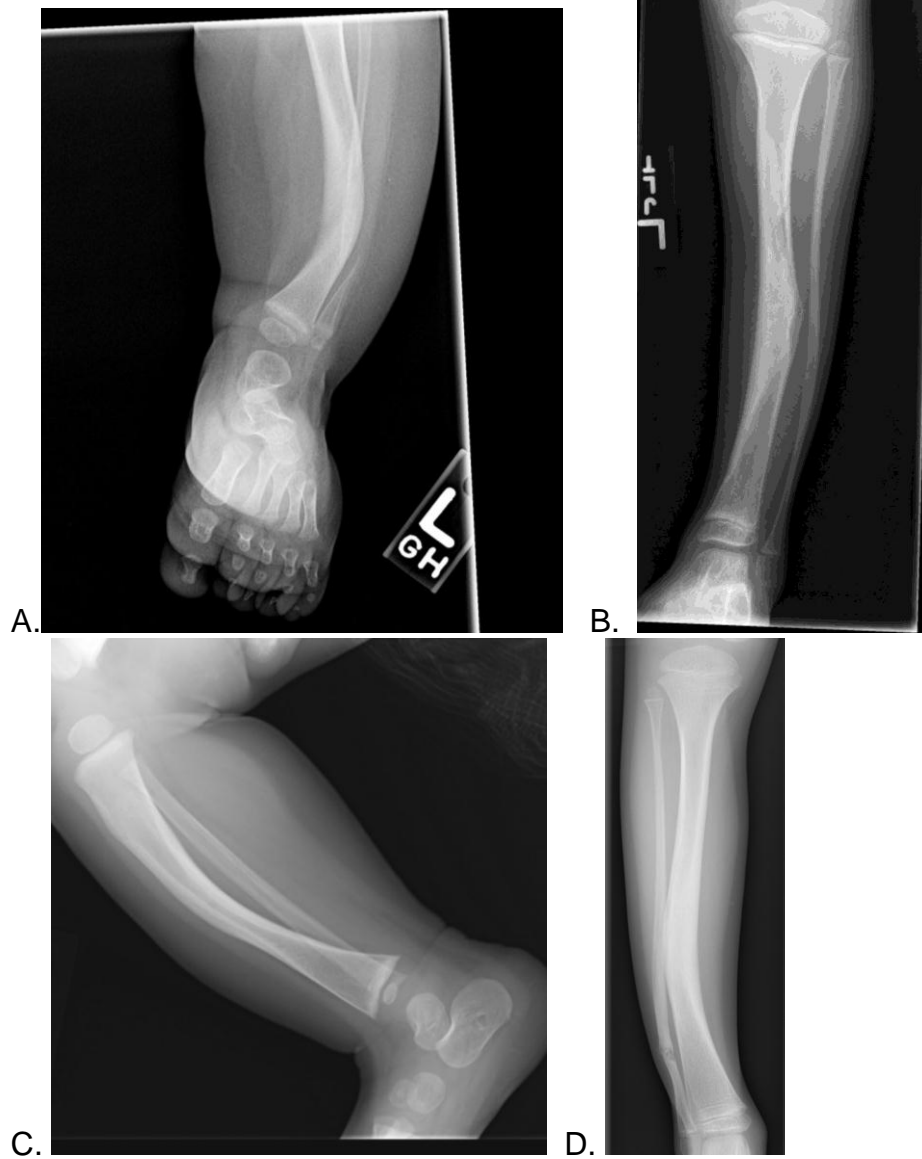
Examples of radiographs (A-D) of the bowed leg of different individuals with NF1 with tibial dysplasia who have enrolled.
